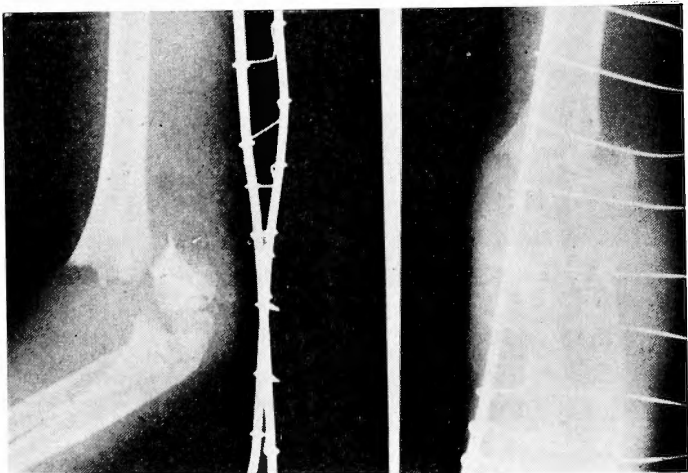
Case #5 Roentgenological findings. Supracondylar fracture.
